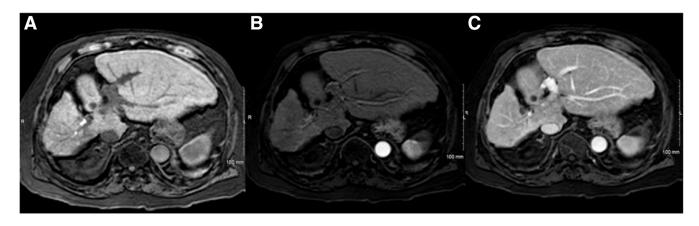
34-month postchemoembolization liver protocol MRI in native (A), arterial (B), and venous (C) phases demonstrating no evidence of recurrent or residual hepatocellular carcinoma.
